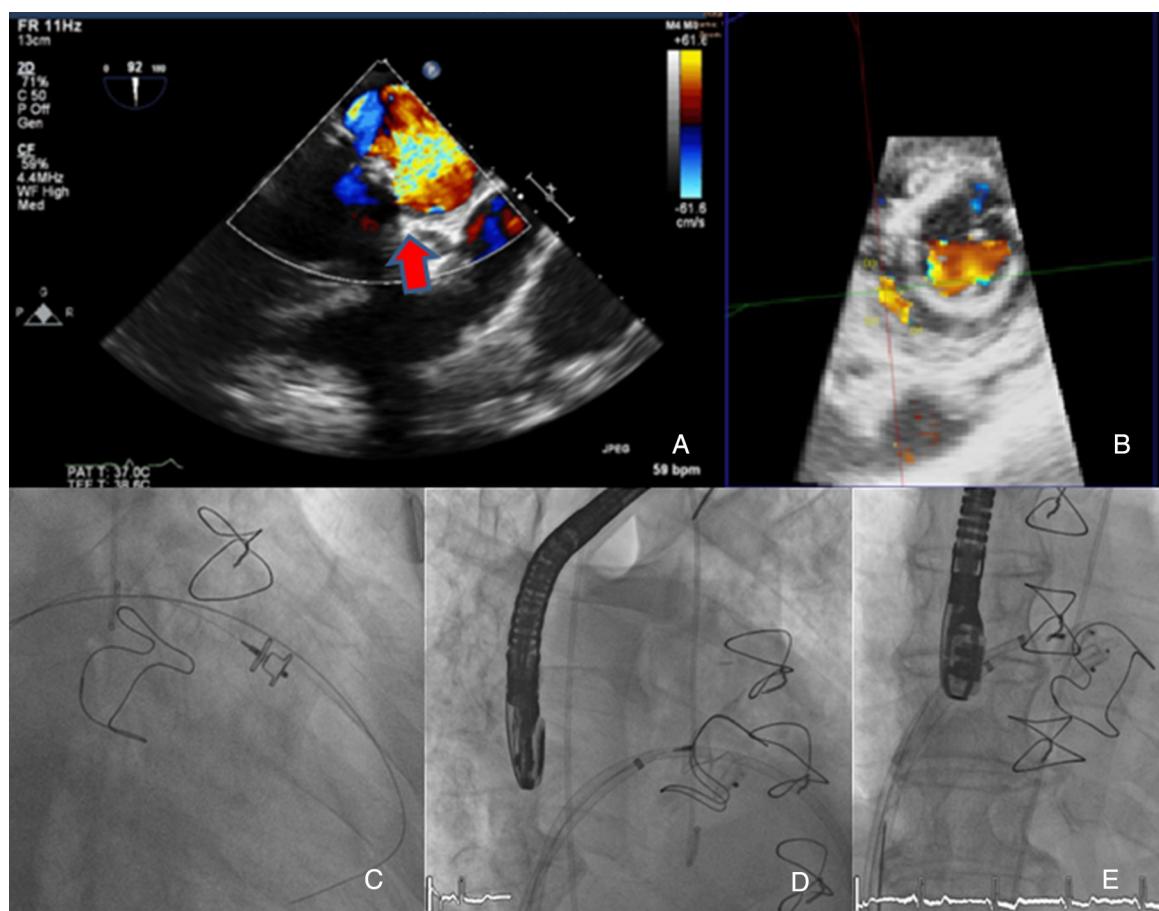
Transesophageal echocardiography showing severe anterolateral paraprosthetic regurgitation (A and B). During percutaneous closure two sheaths were advanced across the mitral leak and an Amplatzer Vascular Plug III (C and D) and an Amplatzer Duct Occluder (E) were deployed.
